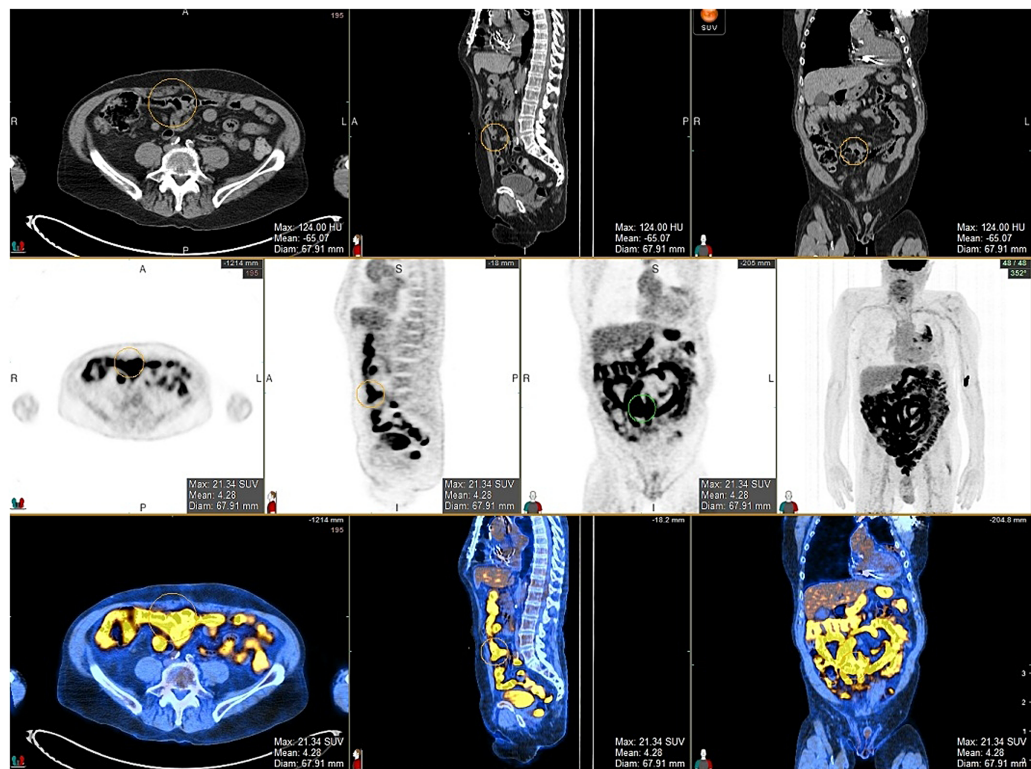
Multiplanar CT, PET and overlay images of the abdomen reveal intense uptake of 18-FDG throughout the visualised bowel, secondary to metformin therapy.
